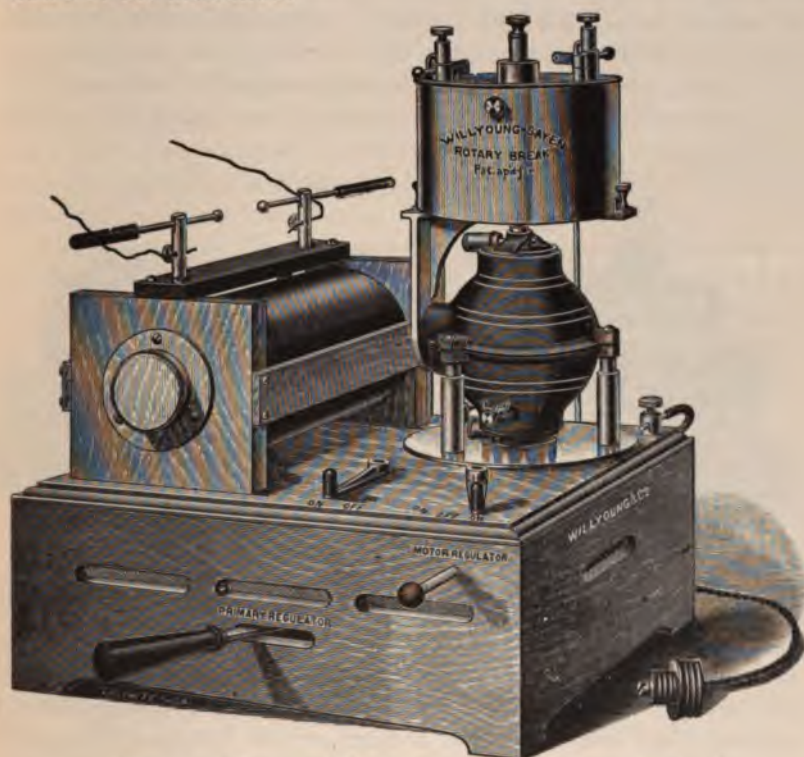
Willyoung's X-Ray Apparatus with Rotary Break.
